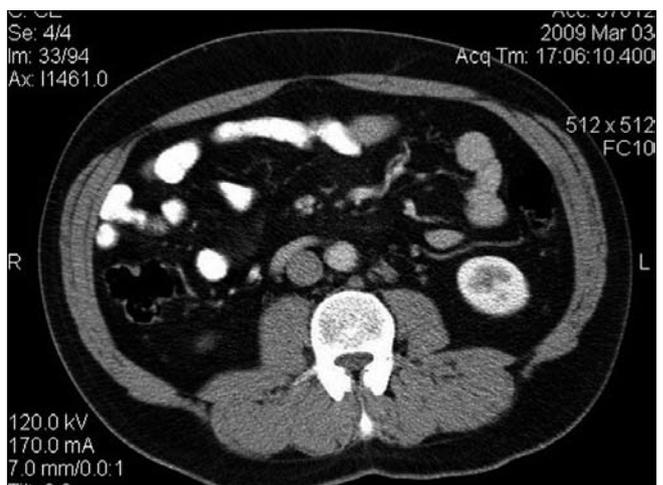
Enlarged retroperitoneal lymph node – CT scan, March 2009.
